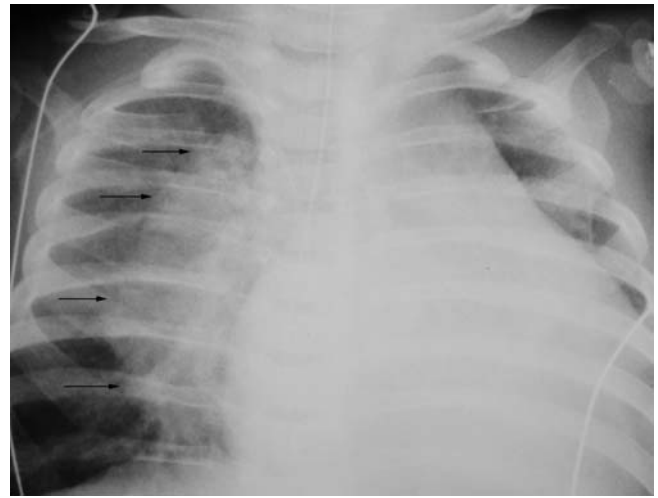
Radiograph of the chest shows a large mass (*arrows*) on the right. Lack of obscuration of the heart border and slight widening of some posterior intercostal spaces (*asterisks*) suggest posterior location. The heart is moderately enlarged. A nasogastric tube is present
